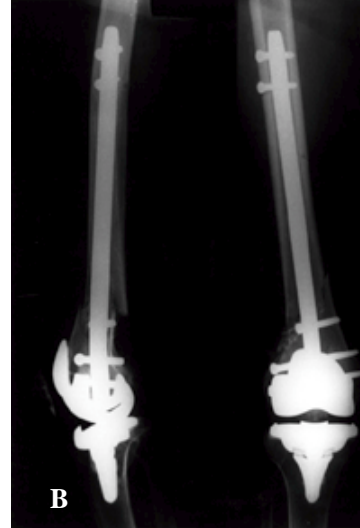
Postoperative anteroposterior and lateral radiographs showing the fracture fixed with retrograde supracondylar intramedullary nail.
